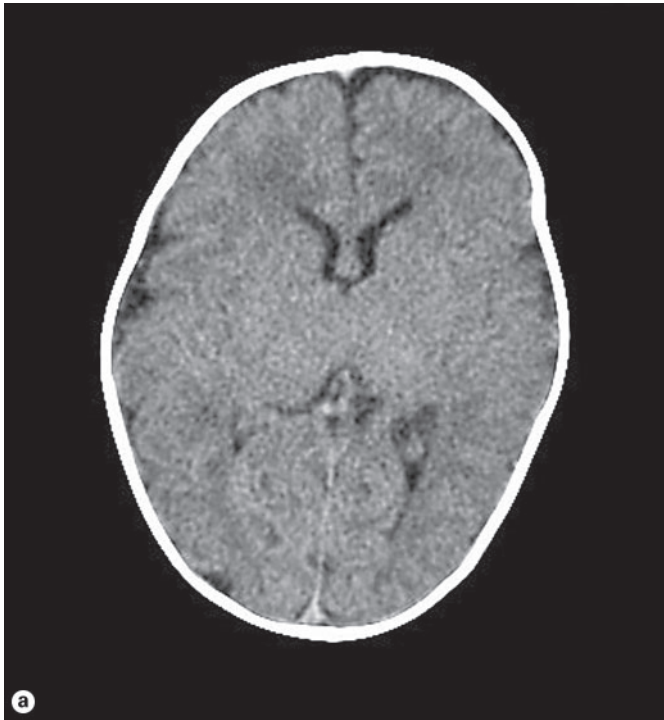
a CT scan at 6 weeks of age without intravenous contrast shows no evidence of tumor, hemorrhage, or hydrocephalus. b CT without contrast 6 weeks later when the patient presented with spontaneous onset of a generalized seizure. A large acute hematoma and hydrocephalus are present within the lateral and third ventricles. c T₁-weighted MRI shows acute hemorrhage, but no evidence of underlying mass.
